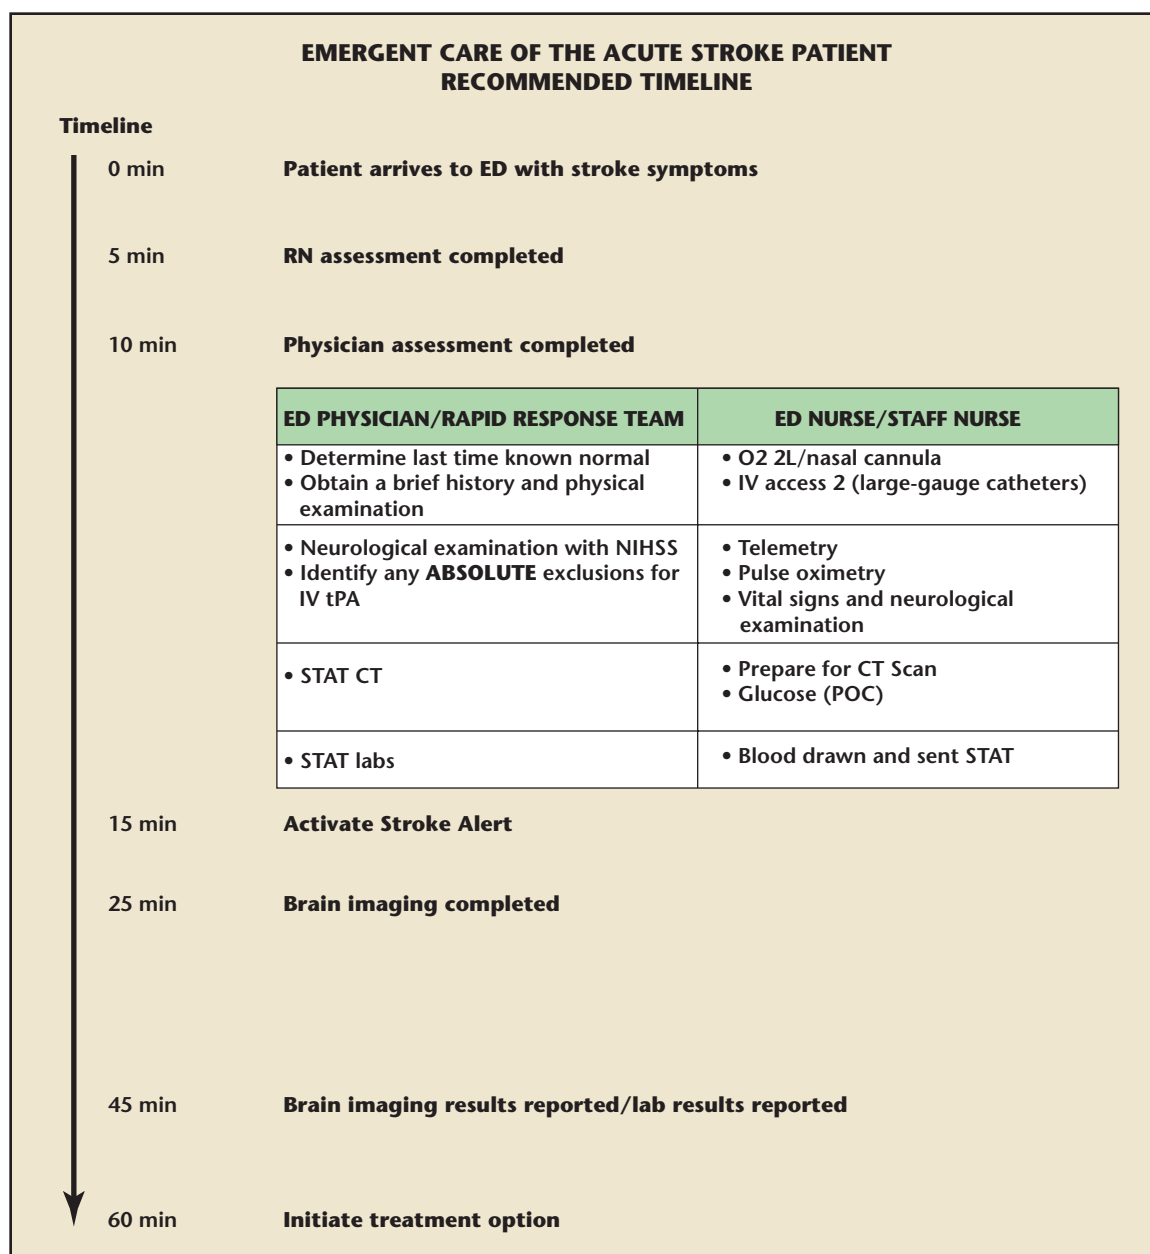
Recommended time line for Code Stroke Alert. CT, computed tomography; ED, Emergency Department; IV, intravenous; POC, point of care; RN, registered nurse; STAT, immediate; tPA, tissue plasminogen activator.
